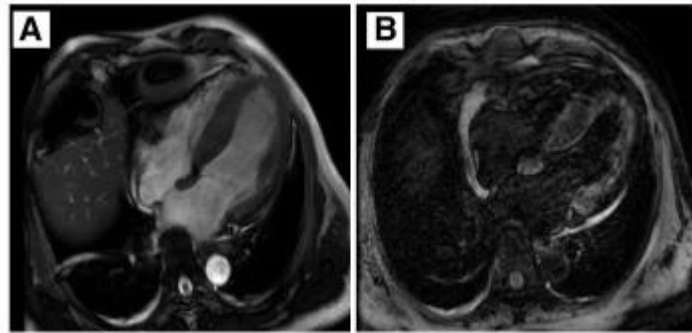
(A, B) Cine and Late gadolinium-enhanced MRI
